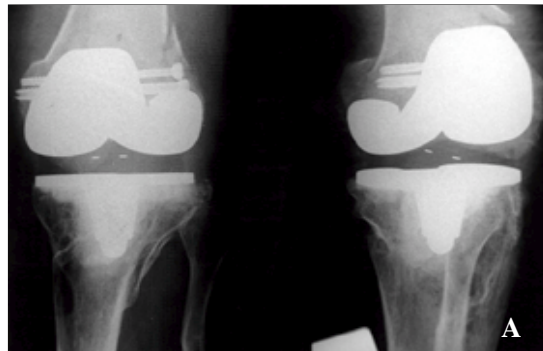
Postoperative both oblique radiographs of a 40-year-old male with a supracondylar femur fracture following TKA, showing the fracture fixed with cannulated screws and unreduced and displaced.
